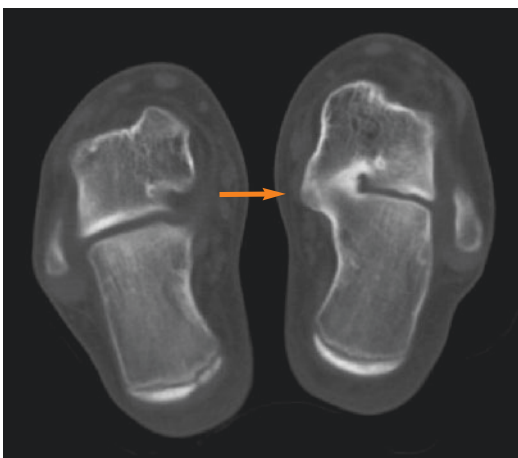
CT-scan foot: tarsal coalition on the medial side of the right foot between the calcaneus and talus (*arrow*)
